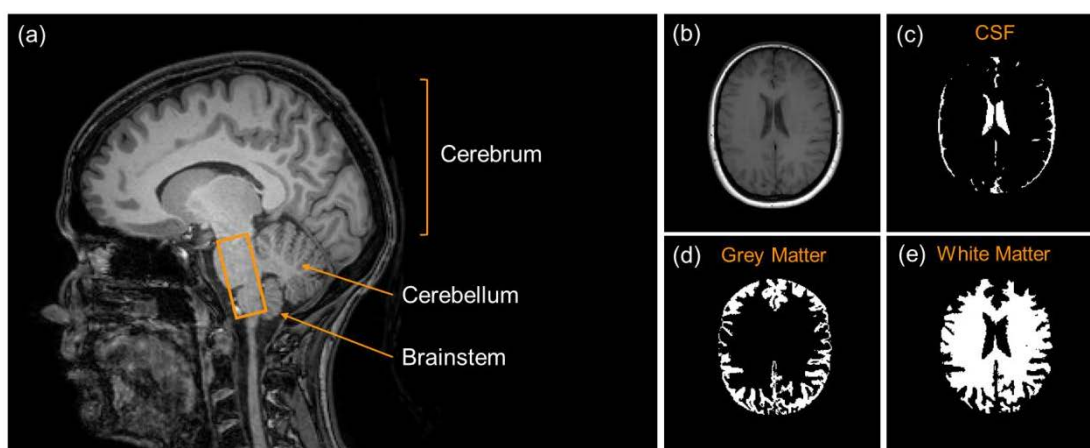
The main brain structures and regions. MR images of the brain (a) main structures: cerebrum, cerebellum and brainstem and regions of the brain on (b) T₂-weighted image and the segmented regions of (c) cerebrospinal fluid, (d) grey matter and (e) white matter.
